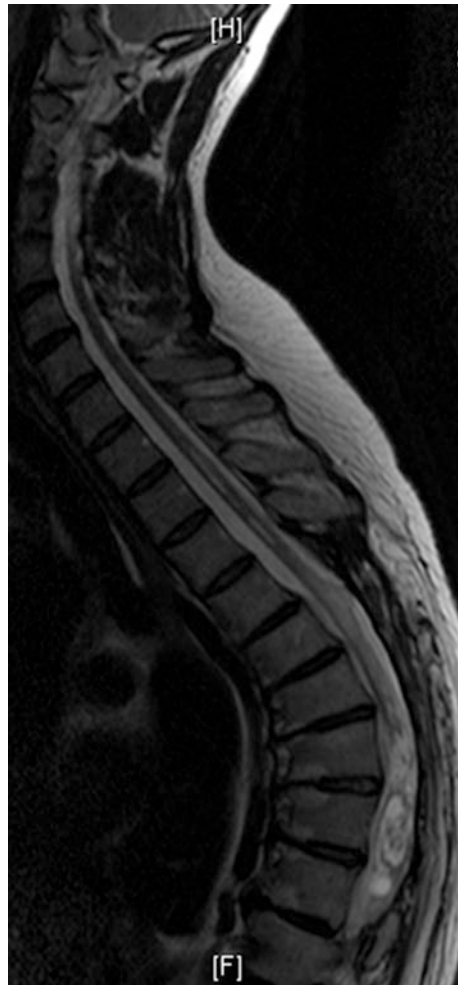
A 41-year-old patient with paraparesis Th2 (AIS D) caused by an astrocytoma (WHO grade II) in the thoracic spinal cord. Sagittal T2-weighted image shows heterogenous signal changes and cyst formation rostral to the solid tumor
